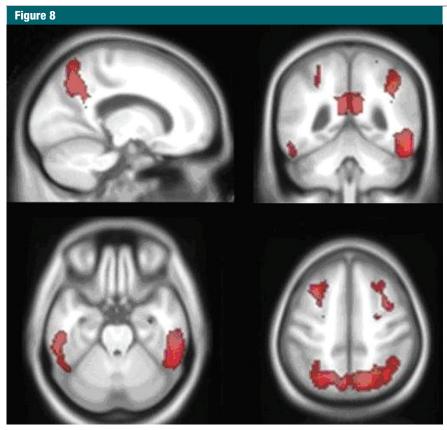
Perfusion MR imaging in AD patients (n = 33) and control subjects (n = 62). Pulsed arterial spin labeling MR imaging (1.5/5.2) shows significant hypoperfusion (red areas) in AD patients, as compared with control subjects. (Reprinted, with permission, from reference 175.)
